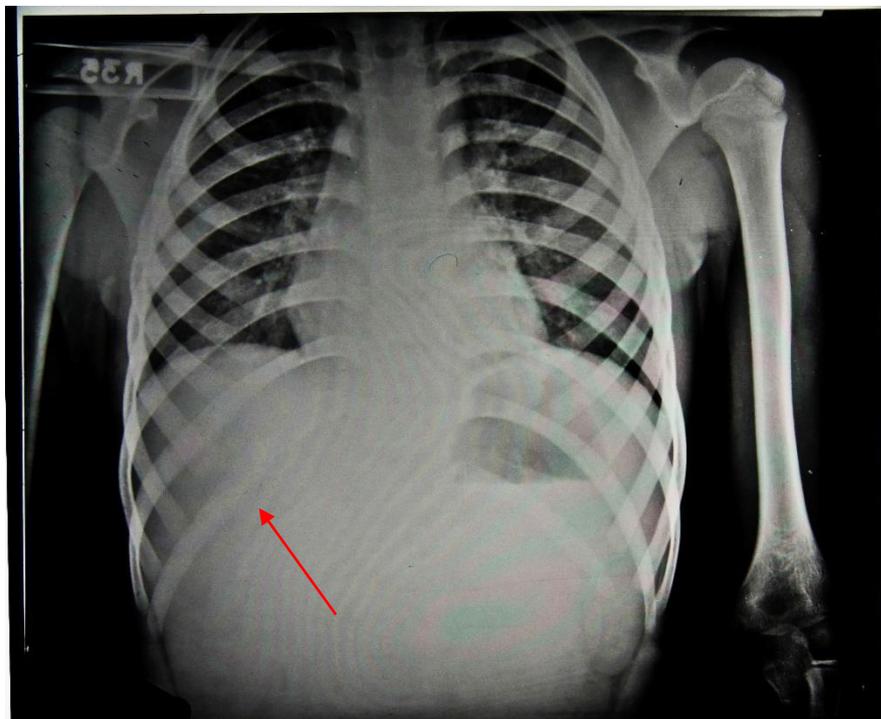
Patient 91/17 diagnosed with a discharging sinus over right rib 10 with suspected underlying bone involvement (arrow). Radiograph report notes no obvious bone lesion seen (HOSP/STAN/7/1/2/693_03)
